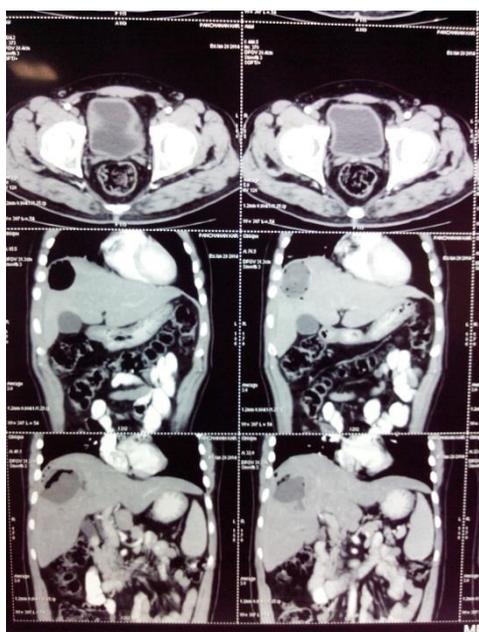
Contrast-enhanced computed tomography scan of the abdomen showing a huge gas-forming abscess with an air-fluid level in right lobe of the liver.
